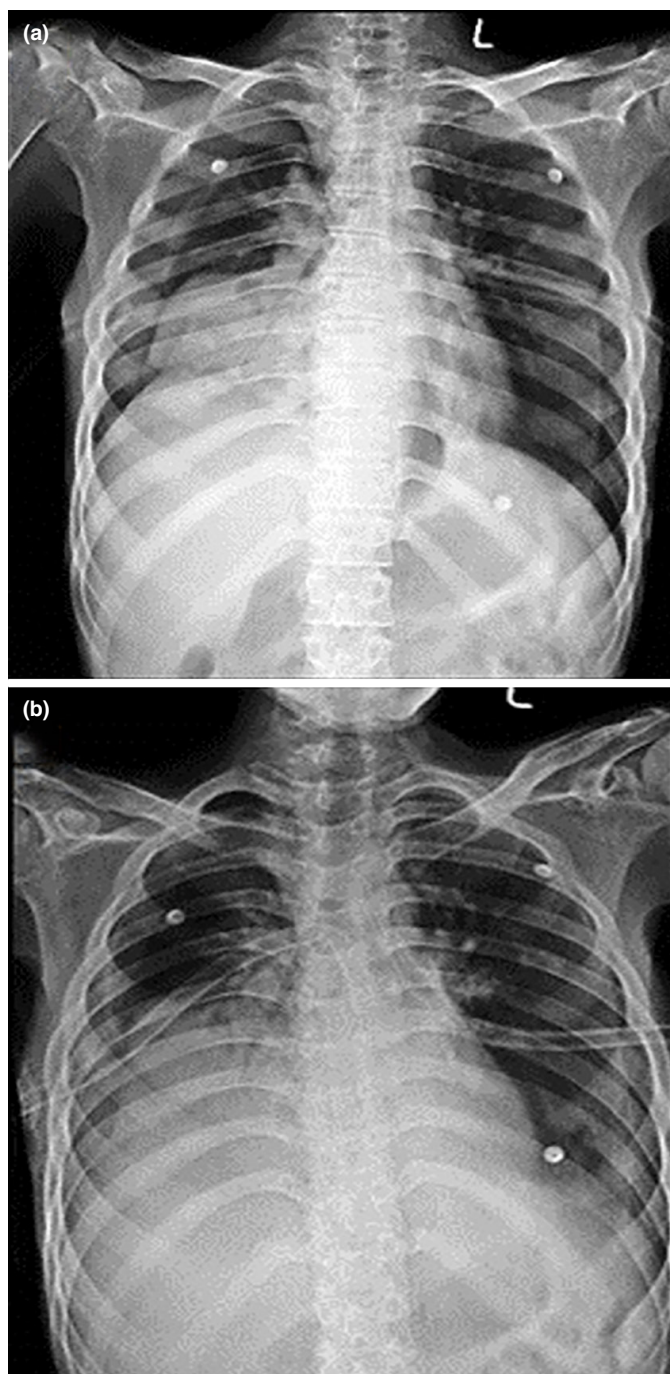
Initial chest X-ray. (a) Initial chest X-ray at reporting time; (b) Initial chest X-ray after admission
